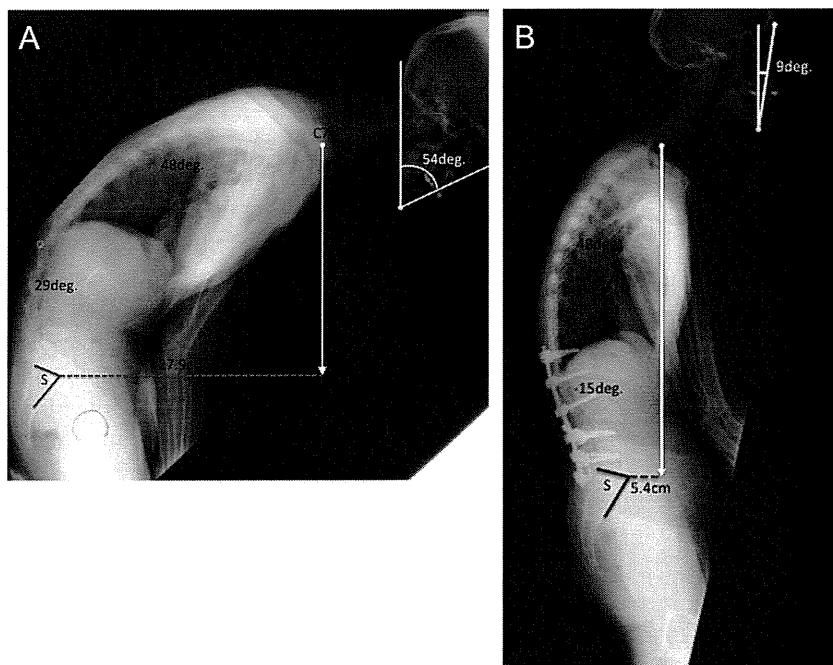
Case 4. Comparison of preoperative (A) and postoperative (B) full-length lateral radiographs. Lumbar lordosis, anterior shift of the C7 plumb line, and CBVA were corrected from 29° of kyphosis, 27.9 cm, and 54° to -15° of kyphosis, 5.4 cm, and 9°, respectively.
